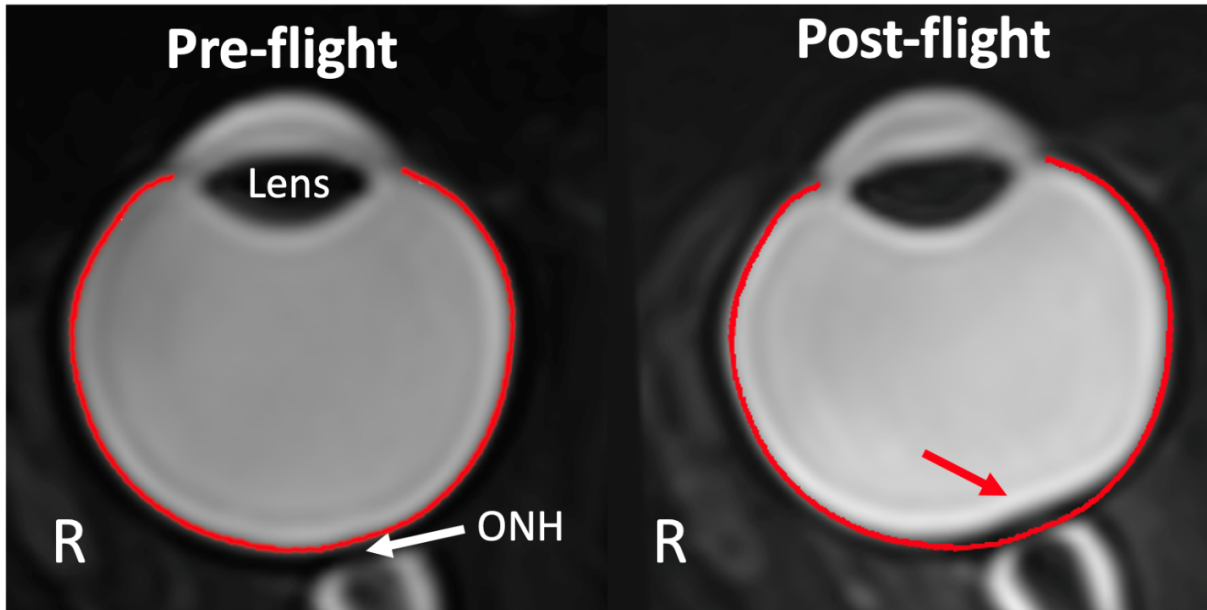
Posterior globe flattening has been identified subjectively and objectively after long-duration spaceflight and as a major symptom of SANS. A contour (red) is overlaid on a preflight and postflight T2-weighted MRIs to show globe flattening that occurred after long-duration spaceflight.
